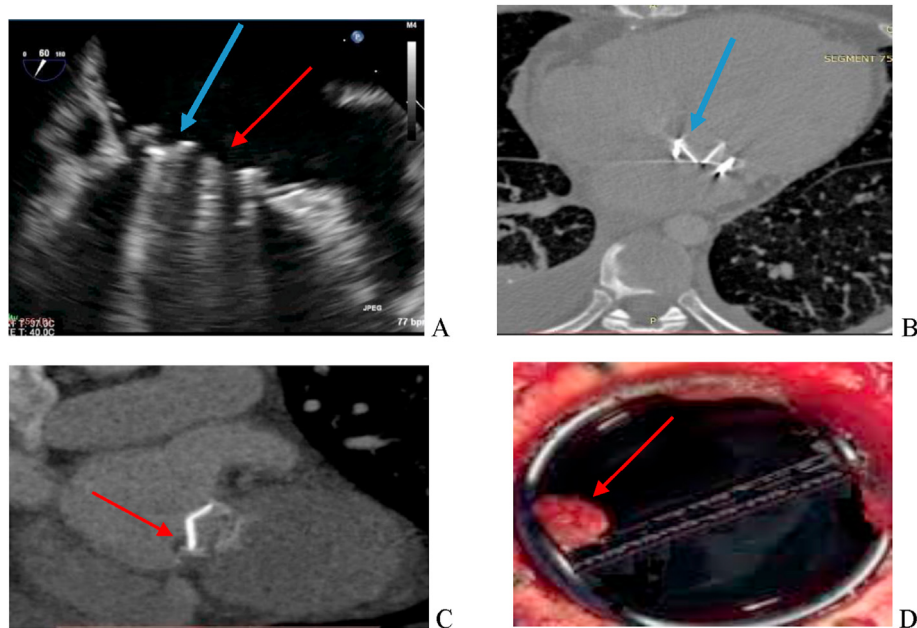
CT and TEE findings in a patient with suspected prosthetic valve malfunction (A): TEE, mid esophageal, two chamber view, the posteromedial occluder (blue arrow) showed malfunction in opening position as compared to anterior one (red arrow) with unknown underlying cause. (B) MCTA, axial cut, four chamber view showing absent excursion of medial mitral occluder (blue arrow) as compared to lateral one. (C): MCTA, coronal cut, two chamber view showing small hypoechoic thrombus attached to atrial aspect of mitral occluder that is not apparent by TEE (red arrow). (D): Surgical image for mitral prosthesis occluder thrombus (red arrow).
